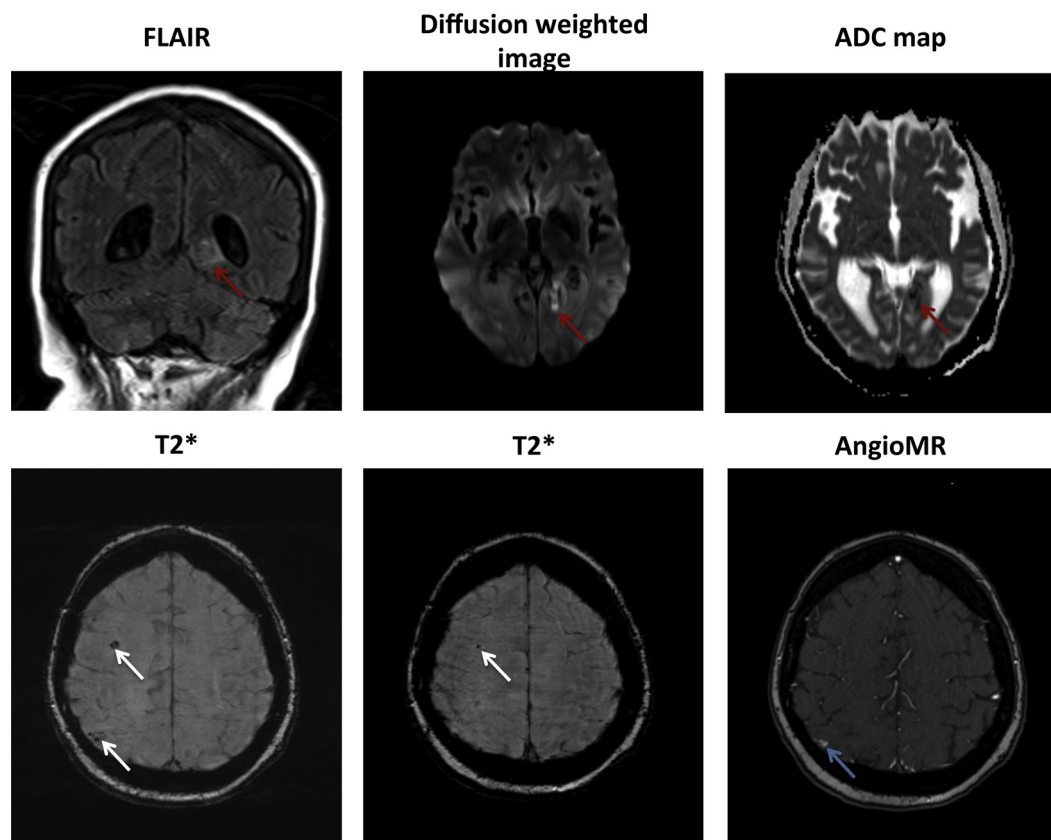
Cerebral magnetic resonance imaging in a patient with infective endocarditis. The FLAIR, diffusion weighted, and ADC map images show a recent ischemic cerebral event (red arrows). The T2* sequences show intracerebral microhemorrhages (microbleeds, white arrows). Angiography magnetic resonance (AngioMR) shows a right occipital infectious (mycotic) aneurysm (blue arrow). ADC, apparent diffusion coefficient; FLAIR, fluid attenuated inversion recovery.
